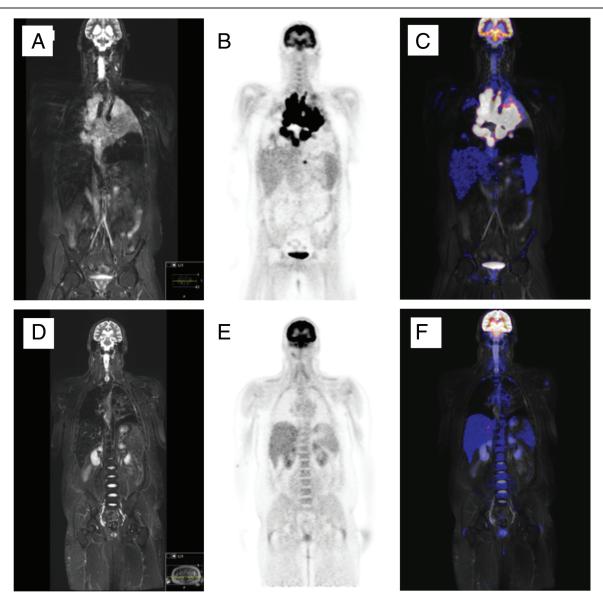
Positron emission tomography (PET)-magnetic resonance imaging was used to reduce ionizing radiation considering the patient's underlying DNA repair disorder. Representative coronary images (A, D: STIR; B, E: PET; C, F: Fusion) are shown before (upper row) and after (lower row) 6 cycles of chemotherapy. STIR = short inversion time inversion recovery.
